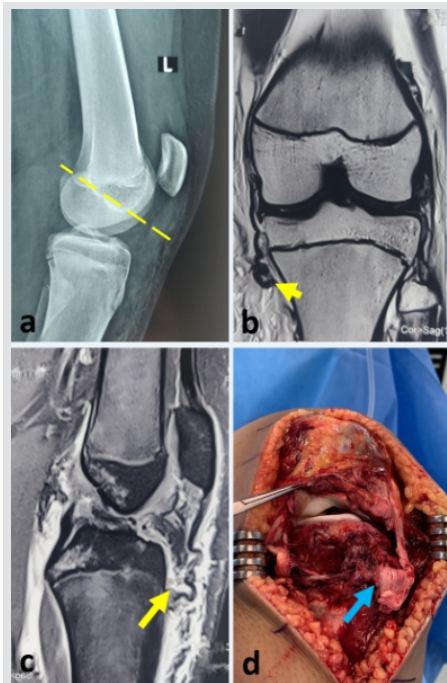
A case of KDIV Injury with Patella Tendon Rupture. (a) Lateral radiograph in 30° knee flexion showing the Blumensaat line (yellow). The patella is riding higher, instead of touching the line at its lower pole. This is indicative of patella alta secondary to a patella tendon rupture. (b) MRI scan T2-weighted coronal section showing tibial sided avulsion of MCL (yellow arrow). (c) MRI scan Proton density fat-saturated sagittal section showing disruption of the patella tendon close to the tibial tuberosity (yellow arrow). (d) Intra-operative image of the same patient showing a complete tear of the patella tendon (blue arrow), along with injury to the MCL, medial retinaculum and capsule.
